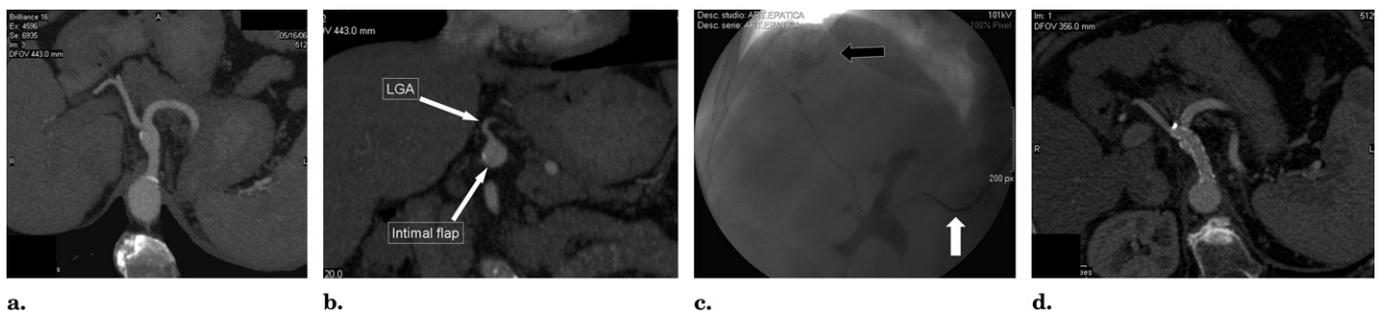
(a) Contrast-enhanced axial CT scan shows a focal 1.4-cm celiac artery aneurysm with an intimal flap and a false lumen causing a smooth narrowing of the ostium of the common hepatic artery. (b) Coronal enhanced CT scan perpendicular to the celiac long axis shows the false and true lumen divided by the intimal flap and the left gastric artery (LGA) originating from the false lumen. (c) Angiogram shows regional transarterial chemotherapy infusion for hepatocellular carcinoma (black arrow) performed with a coaxial microcatheter inserted in a guiding catheter through the stent-implanted celiac artery (white arrow). (d) CT scan 28 months after celiac artery stent placement shows patency of the celiac artery.
